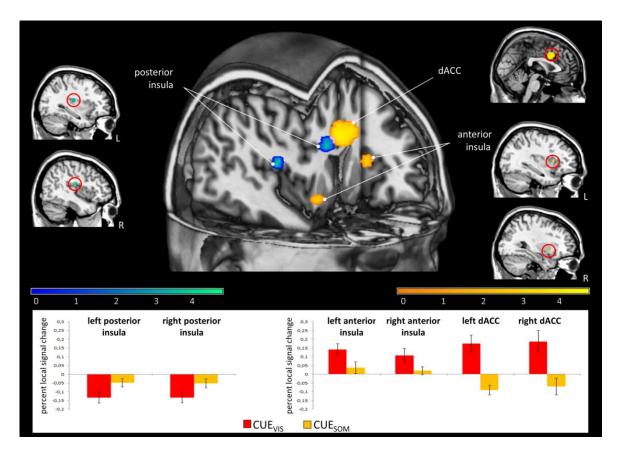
Functional relation between cue- and pain-induced neural responses. Differences in cue-induced neural responses during pain anticipation [CUE_{VIS} < CUE_{SOM}: blue-green] in the posterior insula significantly predict pain-induced neural responses [PAIN_{VIS} > PAIN_{SOM}: yellow-orange] in key nodes of the salience network [in all contrasts: $p_{FWE} < .05$]. Bottom panel depicts percent local signal changes during (left) pain anticipation and (right) pain processing. For more details on BOLD data analyses, see Tab.3 and result section (4.1.3.3.). Activations were superimposed on a structural T1-weighted MRI used for spatial normalization and thresholded at p < .001 uncorrected for visualization purposes. Color bars indicate t-scores. Abbreviations: dACC, dorsal anterior cingulate cortex; SOM, somatic; VIS, visceral.
